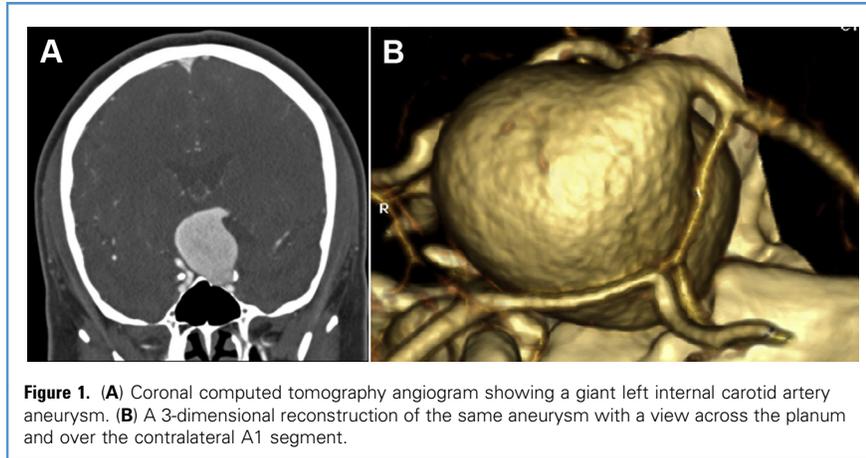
(A) Coronal computed tomography angiogram showing a giant left internal carotid artery aneurysm. (B) A 3-dimensional reconstruction of the same aneurysm with a view across the planum and over the contralateral A1 segment.
